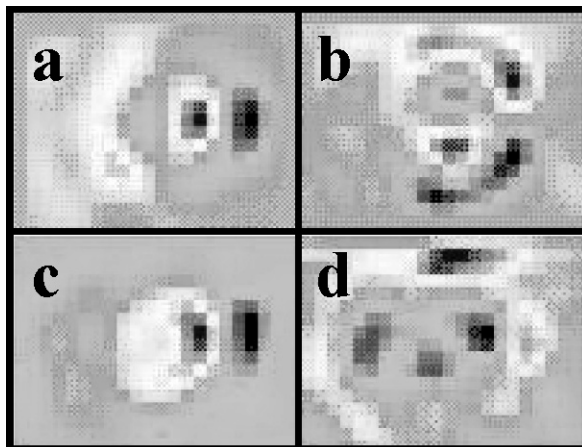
Spatial and temporal scale-space derivatives ($\sigma = 1.42$) obtained from a 2D cross-section of a 3D gated-SPECT image of human heart. Spatial resolution is 30×30 , temporal resolution 16 frames/cardiac cycle. a), b), c) and d) are the derivatives images in x , y , z and time directions, respectively.
